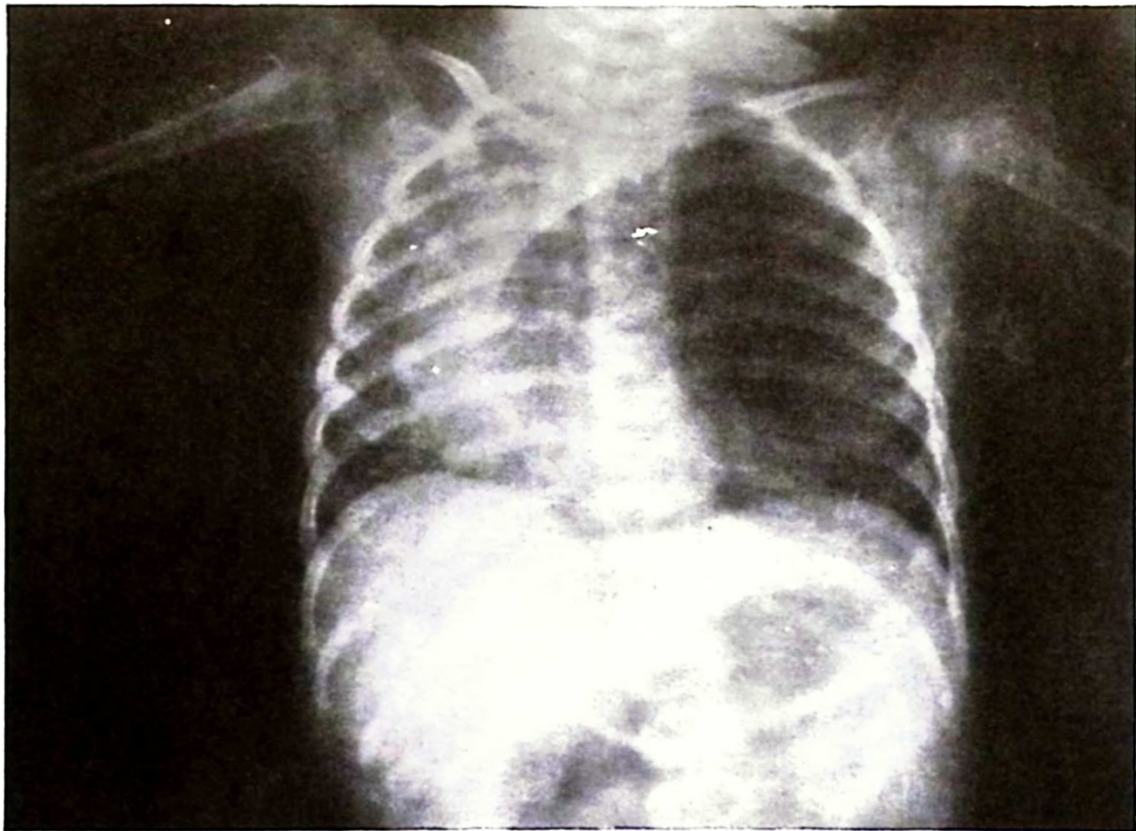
Chest x-ray of Case 2 showing an overdistended, hyperlucent left-upper lobe with mediastinal and cardiac shift, and herniation of the left lung into the right hemithorax.
